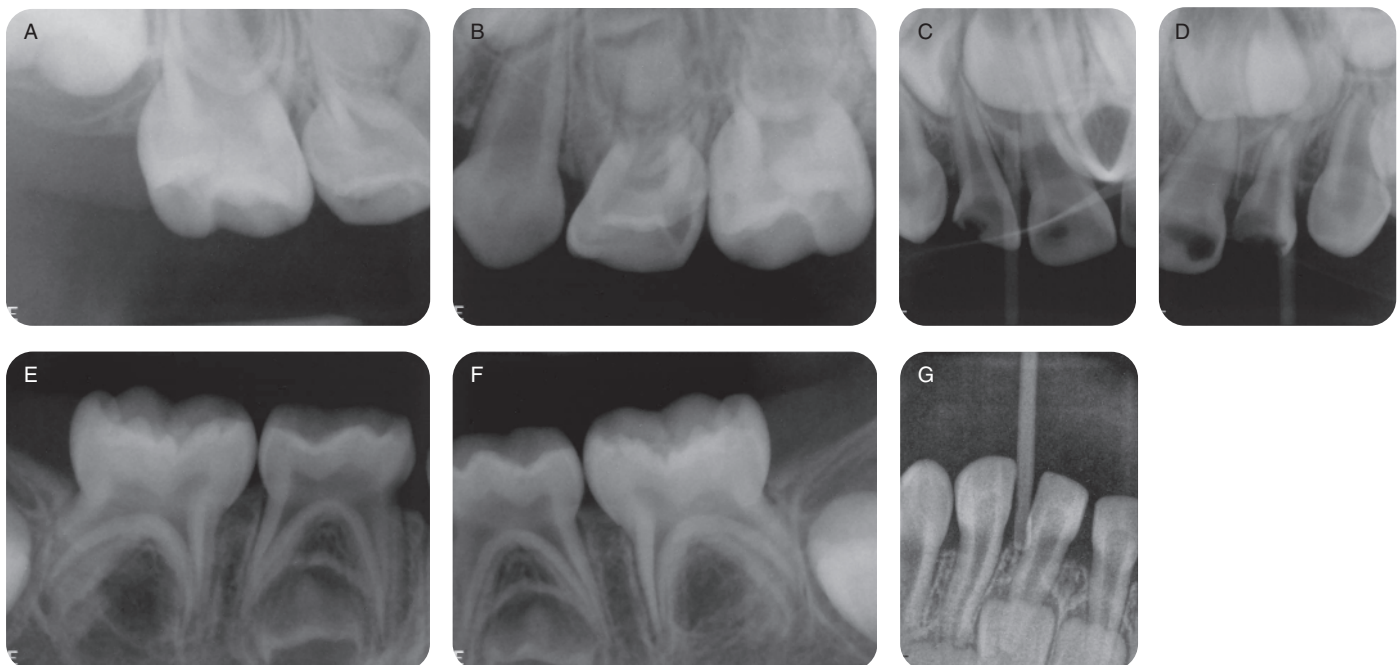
Pre-op intra-oral radiographs
